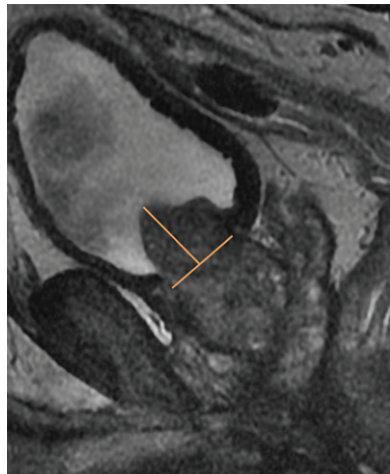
Sagittal T2-weighted MR image in a 70-year-old man shows calculation of the intravesical protrusion of the prostate (IPP), which is 2.2 cm.
